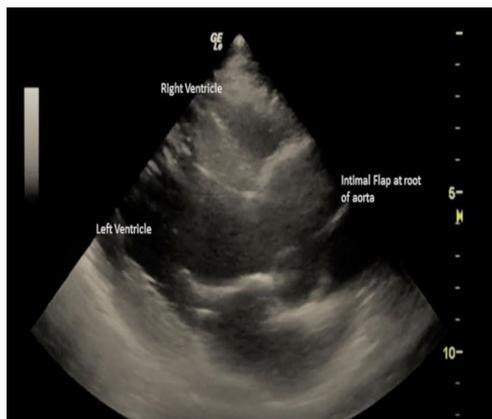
Bedside transthoracic echocardiography parasternal long axis view showing dilated root of aorta with presence of intimal flap.
